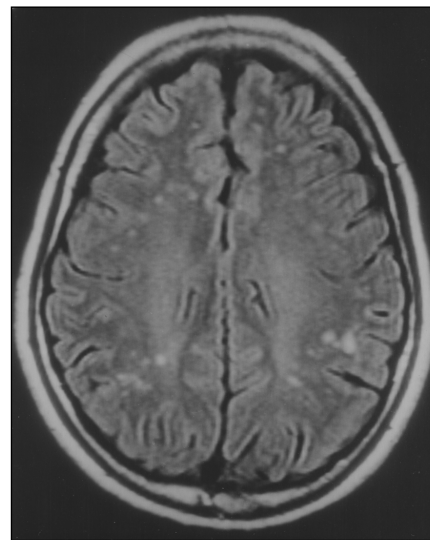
53-year-old man with acute Nipah encephalitis. Axial fluid attenuated inversion recovery MR image shows disseminated discrete round lesions in white matter.
